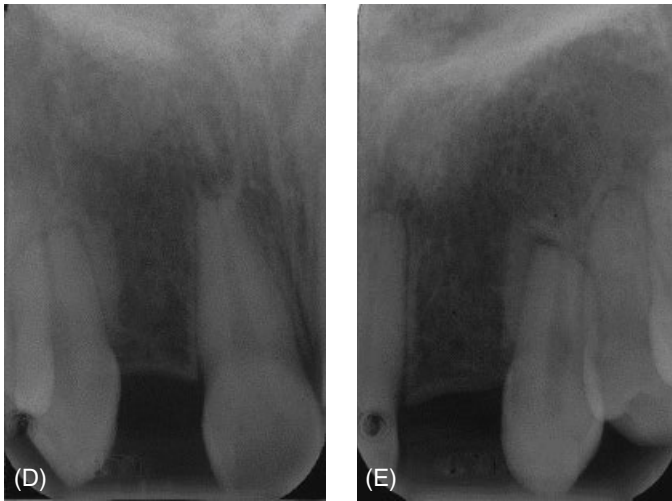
(D, E) Radiographs of the corrected implant sites following orthodontic retreatment.
